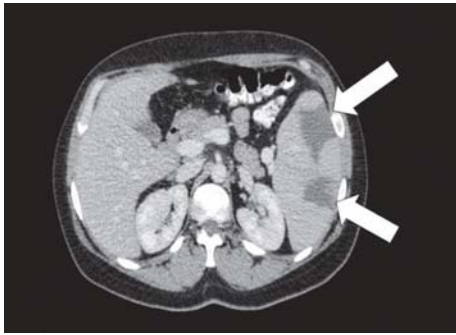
CT scan: two large splenic infarcts, as demonstrated on an abdominal CT scan (white arrows)*
